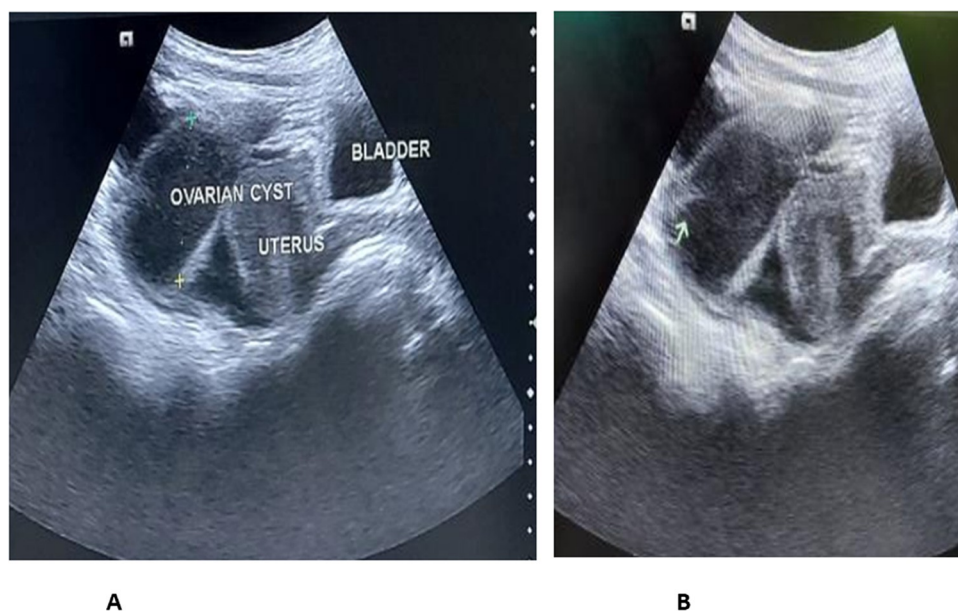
(A and B) Abdomino-pelvic ultrasound demonstrating right-side ovarian cyst with thick wall and solid component and free peritoneal fluid collection.
